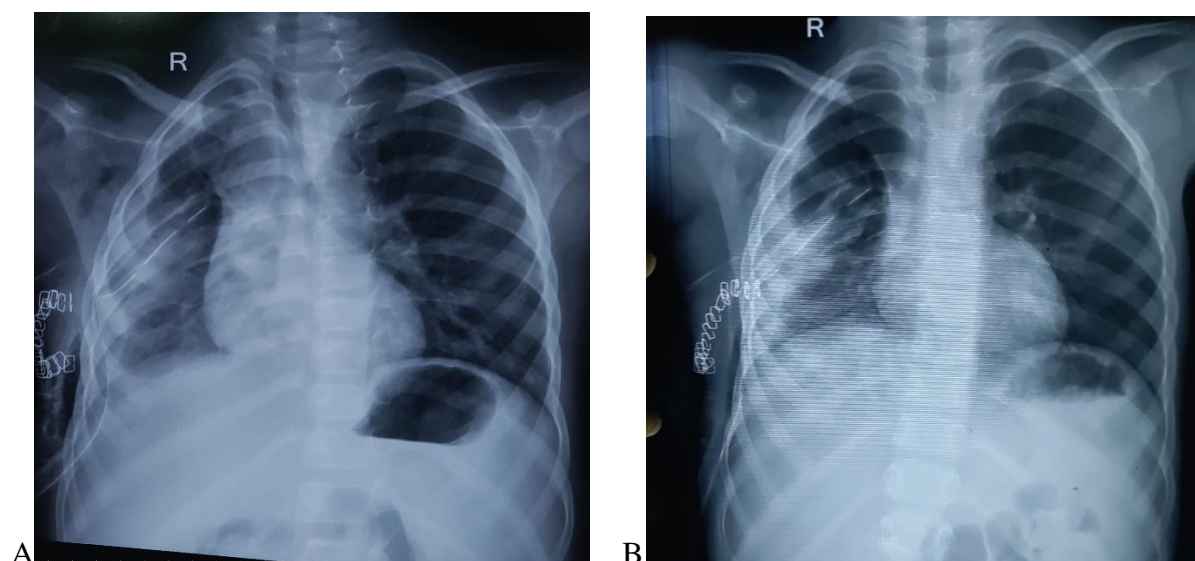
Post operative serial Chest X-rays taken, on (A).POD 1 and (B) On the day of removal of ICD showing lung expansion.
